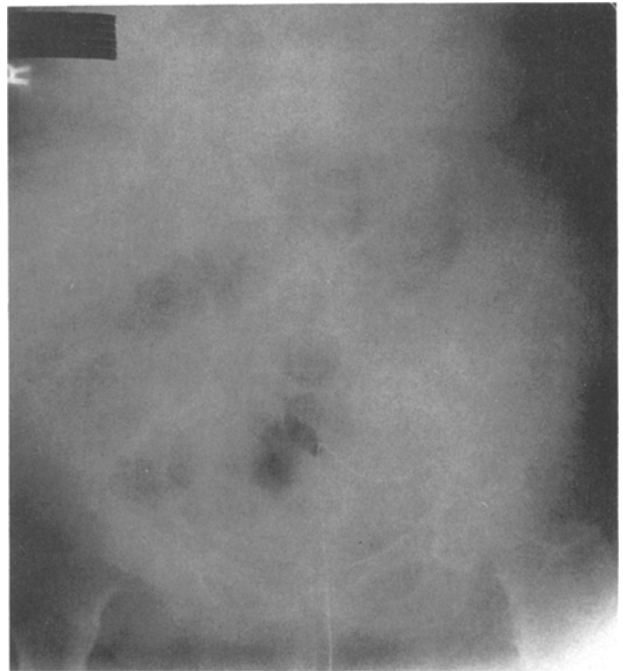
Abdominal radiograph taken following rectosigmoid stent placement reveals intraluminal stent and normal bowel gas pattern.
